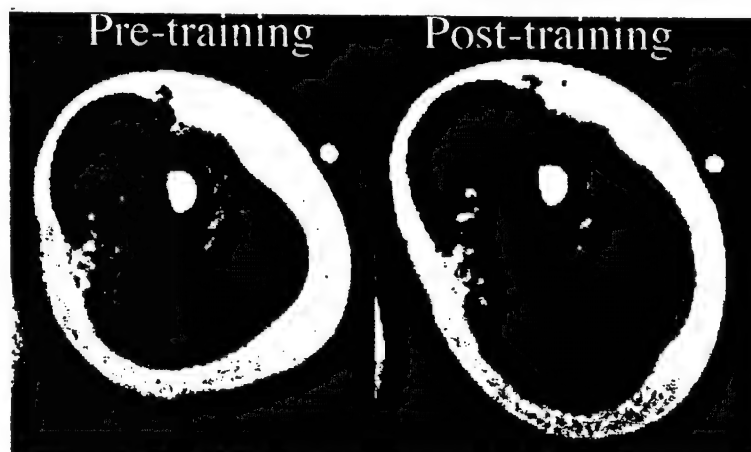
MRI of the AMCSA of subject #40 pre- and post-training showing a 34% increase.
